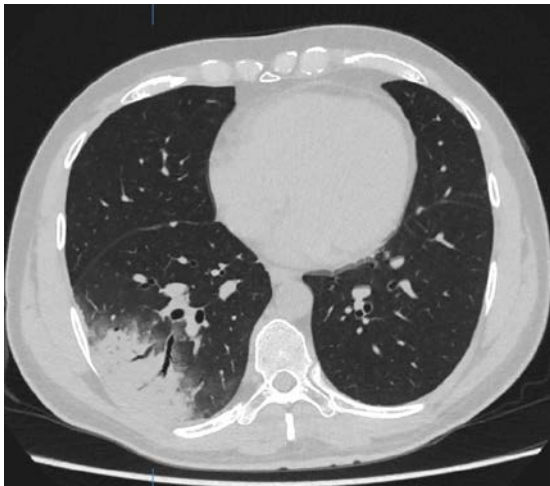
Axial thin-section unenhanced computed tomography (CT) scan shows right unilateral consolidation with air bronchogram with peripheral distribution in the right lower lobe.
